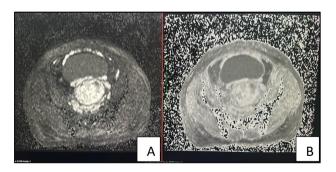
(A and B): AXIAL section showing hyperintensity on DWI and low values on ADC sequences corresponding to diffusion restriction in the highly cellular mass.
